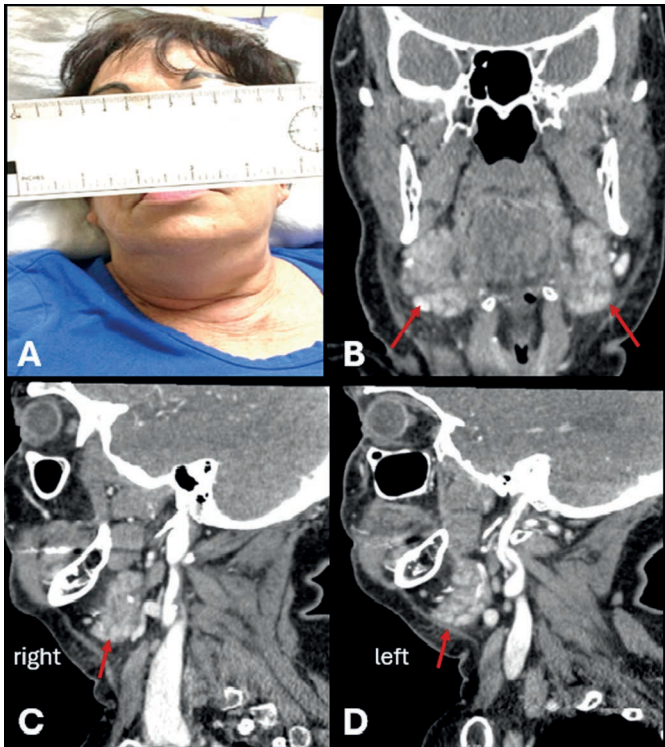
Frontal photograph (A) showing cervical swelling, predominantly in the submandibular regions. Contrast-enhanced CT of the neck, coronal (B) and sagittal (C, D) images. Swelling of the submandibular glands (red arrows) with heterogeneous hyperenhancement, associated with fat stranding in the surrounding planes and reactive thickening of the platysma muscles.
